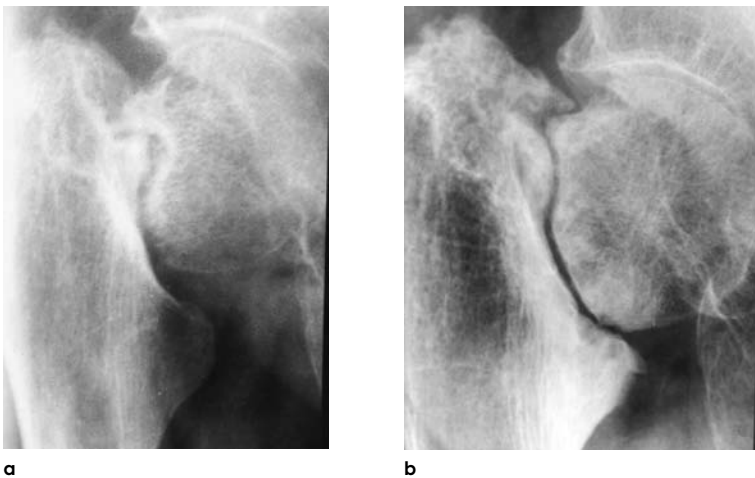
Radiographs of a patient with a cortication of the proximal fracture surface (Kazár, 1963).
